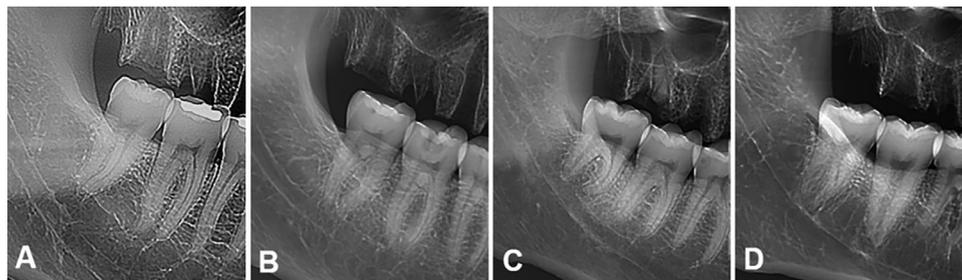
Cropped images of panoramic radiography (PAN) showing the anatomic relationships between the third molar root apex and the mandibular canal, classified as: “distant” greater than 1 mm (A); “distant” 1 mm or less (B); “in contact” (C); and “overlapped” (D).
